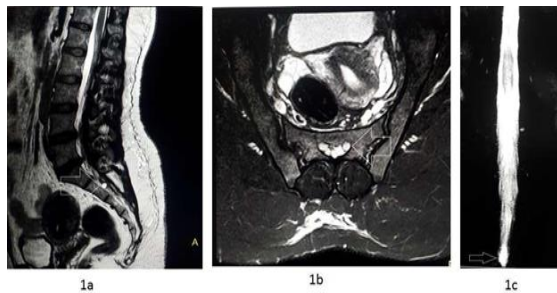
Case #1: MRI Lumbosacral spine of 46-years old male with low backache of two years duration. (a) T2W Sagittal section shows a hyperintense small round lesion as an incidental finding present on the dorsal aspect of S3 vertebral body (white arrow). (b) T2W axial section shows the same lesion as perineural cyst on left side (white arrow). (c) MR myelography shows subtle findings of prominence of the caudal end of the spinal cord (white arrow).
